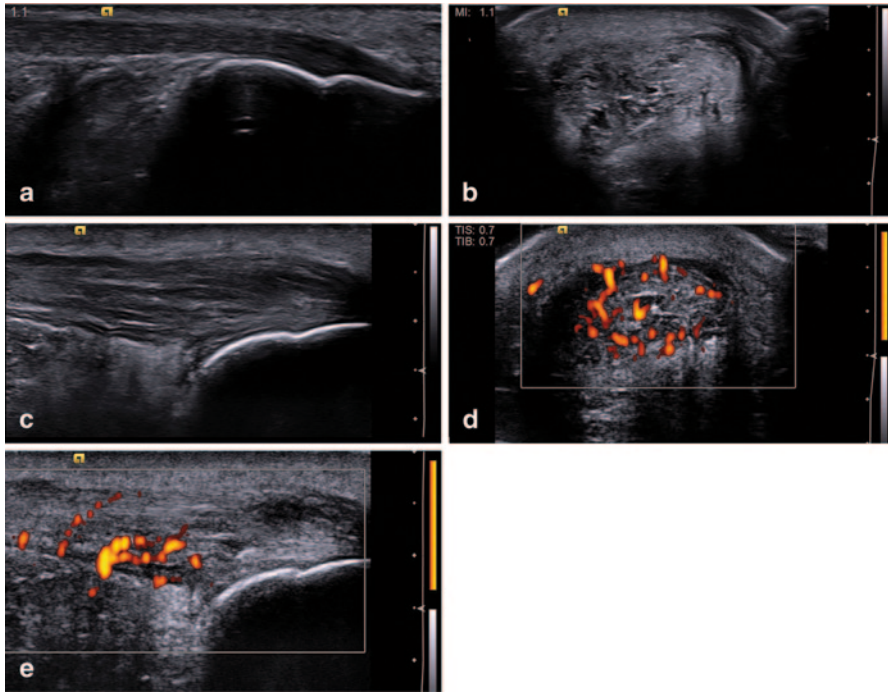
Achilles tendinitis and paratendinitis. (a) Normal Achilles tendon in long axis. (b) Short axis. (c) Long-axis gray scale with increased thickness, hypoechoic changes, fibril separation, edema, and loss of normal tendon boundary. (d) Short axis. (e) Long-axis power Doppler for the same findings with positive signal in and around the tendon
